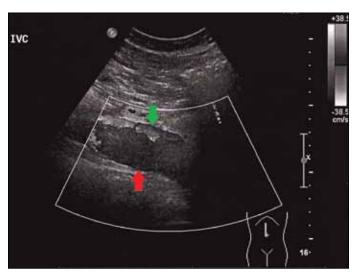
Duplex Doppler ultrasound: longitudinal section of the IVC. This image demonstrates the hypoechoic partially occlusive thrombus within the IVC (red arrow). There is some peripheral flow, most notably anterior to the thrombus (green arrow).
